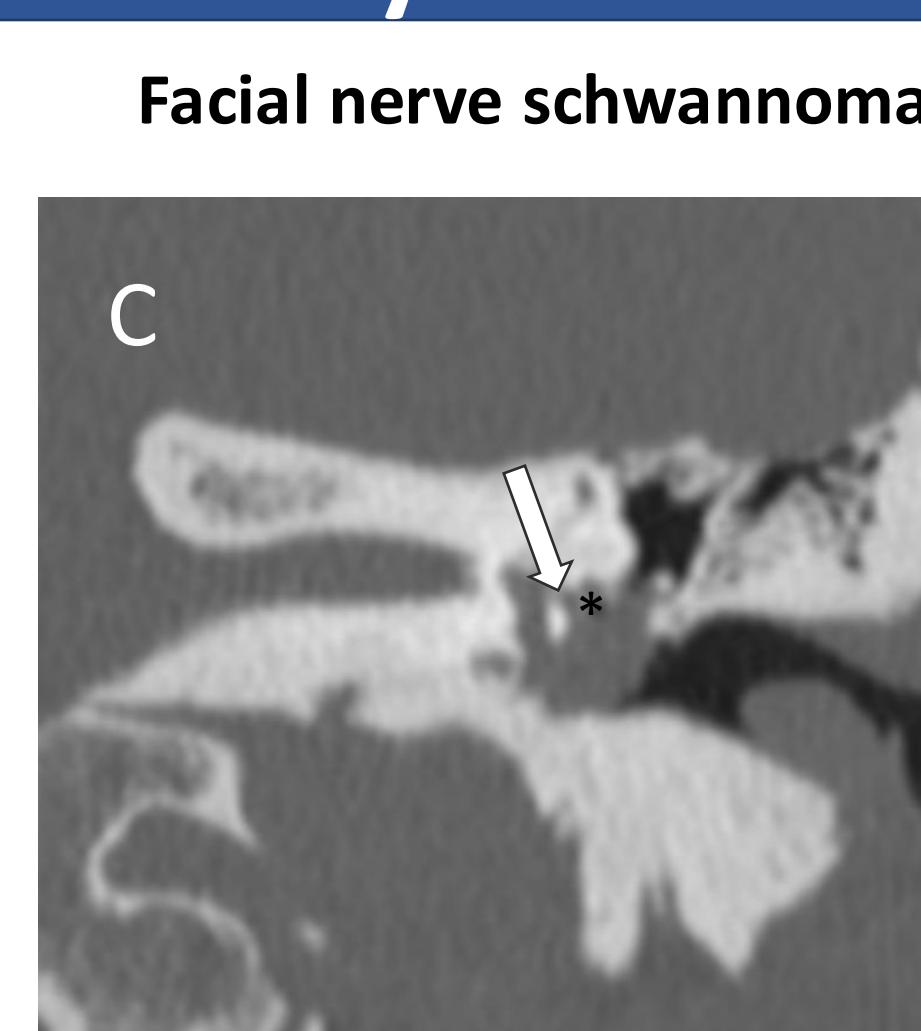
Coronal CT shows an intratympanic soft tissue mass (asterisk) which contacts the tympanic facial nerve canal (arrow).
